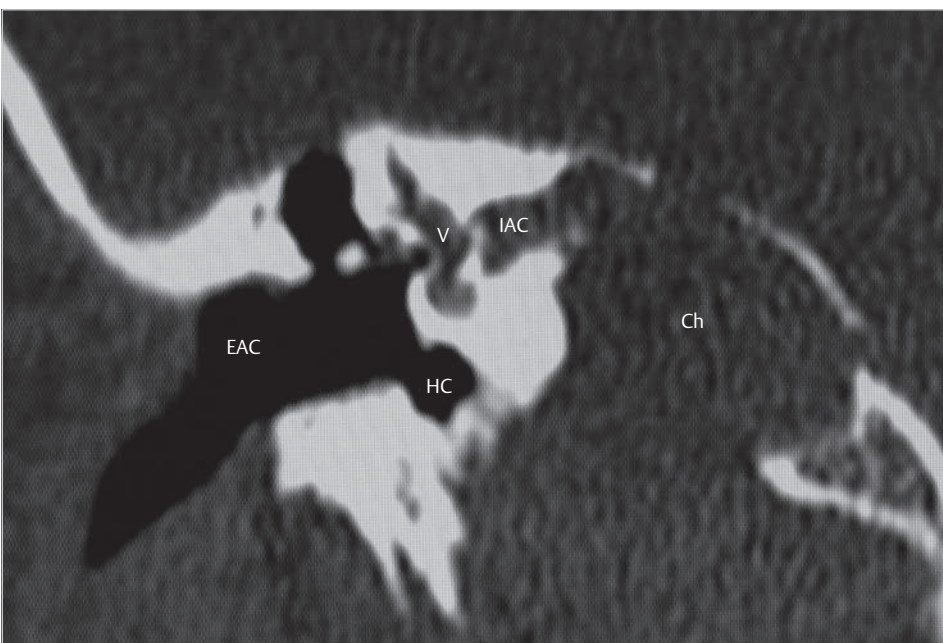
The coronal CT shows infiltration of the hypotympanic cells with the soft tissue. The internal auditory canal is also eroded. Note that no pathology is seen in the middle ear cleft and the mastoid. Ch, cholesteatoma; EAC, external auditory canal; HC, hypotympanic cells; IAC, internal auditory canal; V, vestibule.
